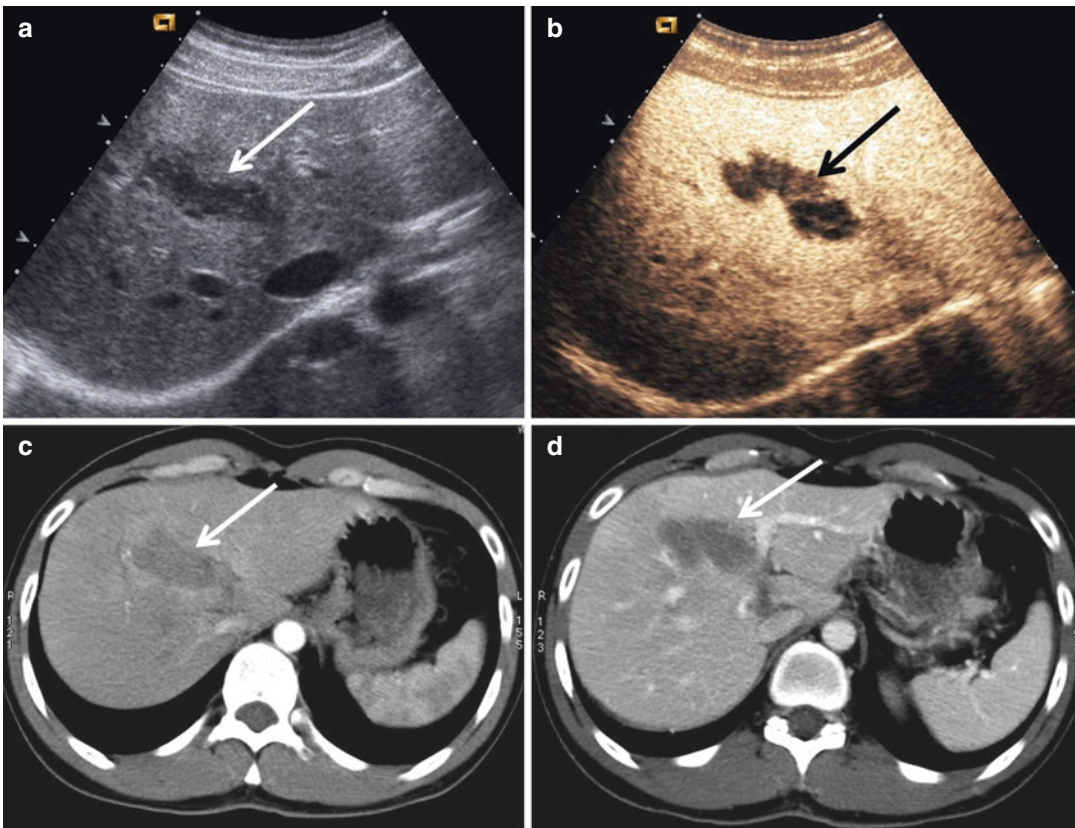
Hepatic laceration. (a) Ultrasound shows a hypoechoic area within the right liver lobe (arrow); (b) CEUS: the laceration appears a nonvascular area (black arrow). The CE-MDCT, in arterial phase (c) and portal
